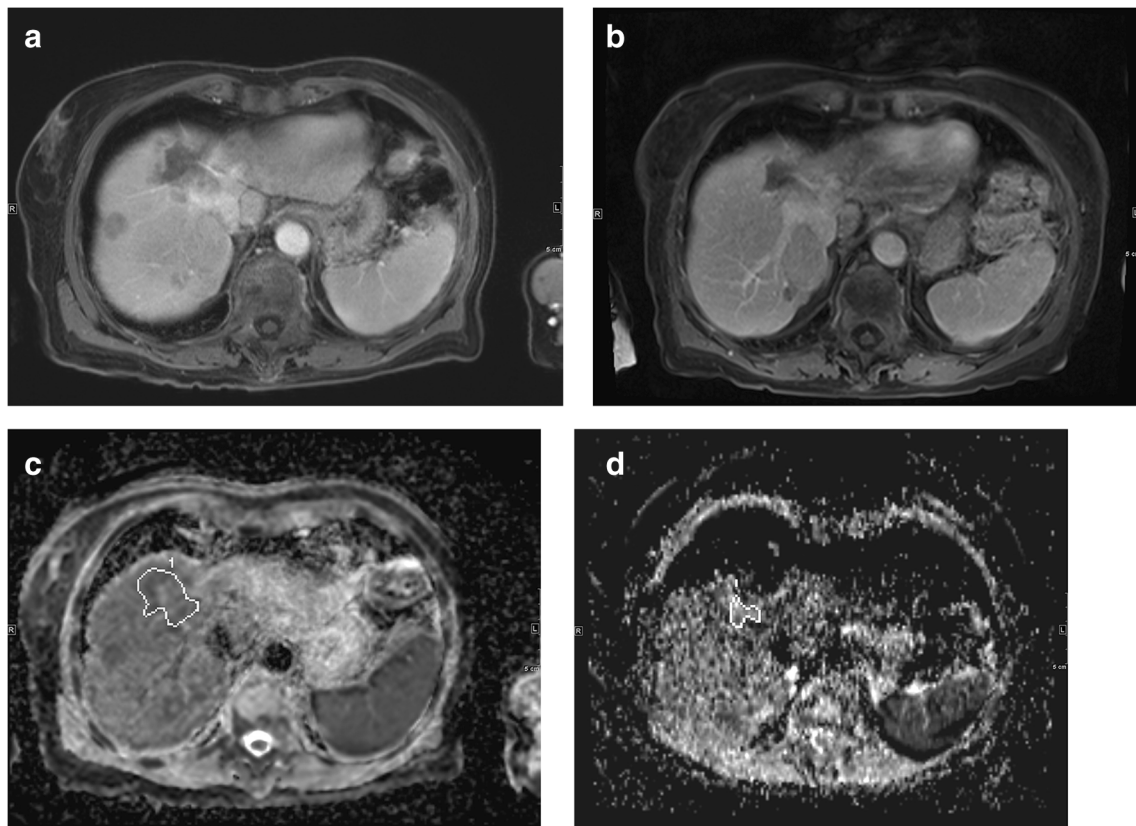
An 81-year-old woman with hepatic metastasis of a colorectal carcinoma. Palliative indication after first being diagnosed in 12/2012 with pT3, pN2a, L1 G3, wild-type K-Ras, and already receiving second-line chemotherapies as well as a sigmoid resection (11/2014) over the last 5 years. Now third-line transarterial chemoembolization (TACE) with mitomycin C, irinotecan, cisplatin as chemotherapeutics, and degradable starch microspheres (DSM) for vessel occlusion. a Pre-treatment contrast-enhanced axial magnetic resonance imaging (MRI)
